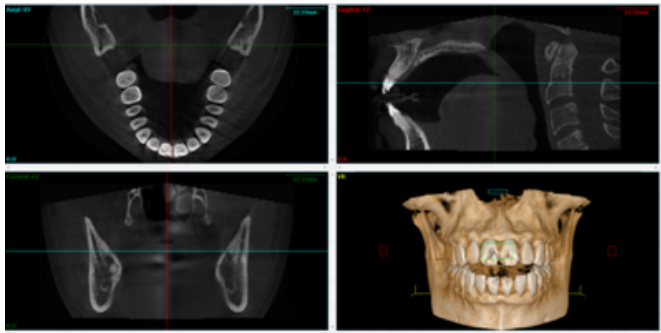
CBCT X-ray (Wikipedia, 2013)
